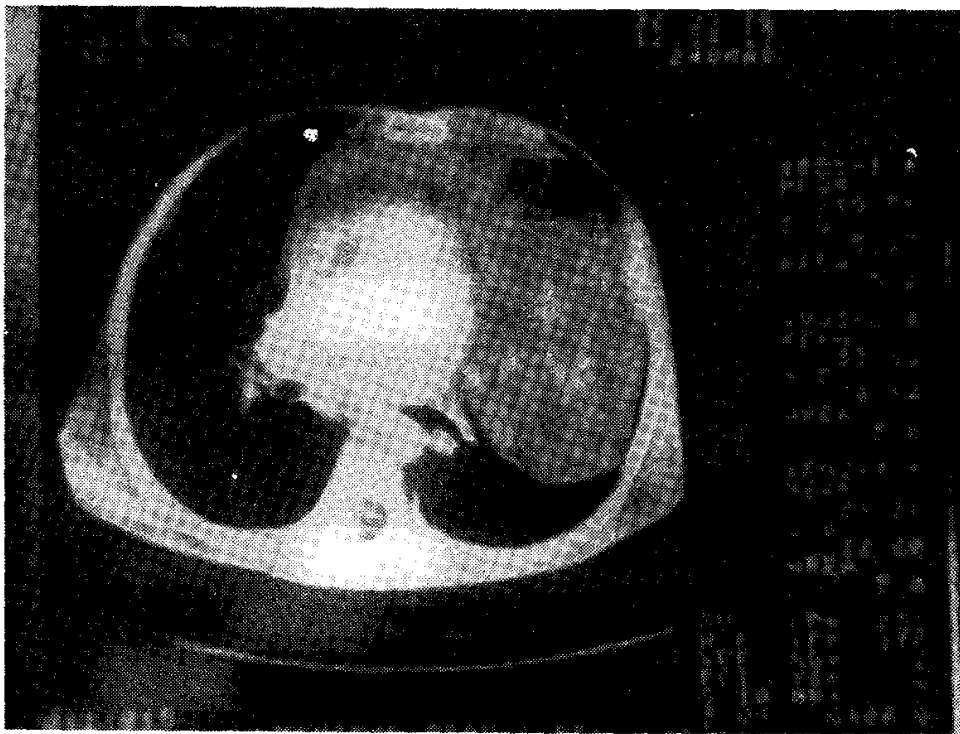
CT scan showing anterior mediastinal mass which is extending into middle and posterior mediastinum. The mass is predominantly hypodense ( $-94$  HU) with areas of soft tissue density ( $53$  HU) within it.
